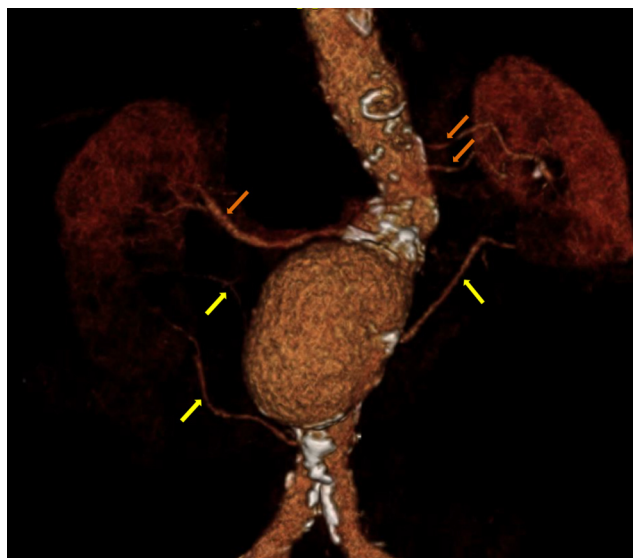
3D-reconstruction from CT-scan showing AAA with multiple accessory renal arteries
